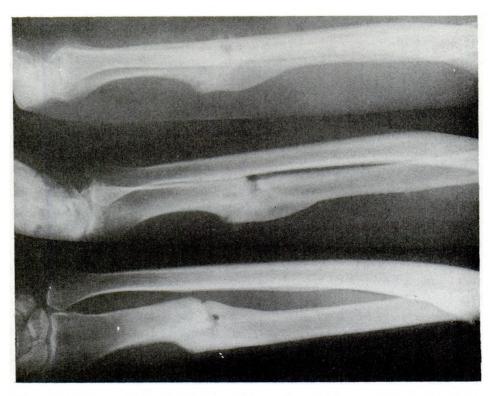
X-ray of a healed fracture (three views taken from different angles).
